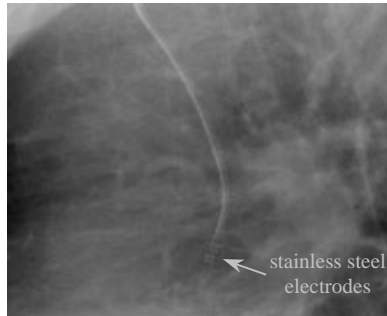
X-ray image of the HemoCard Vision catheter.
